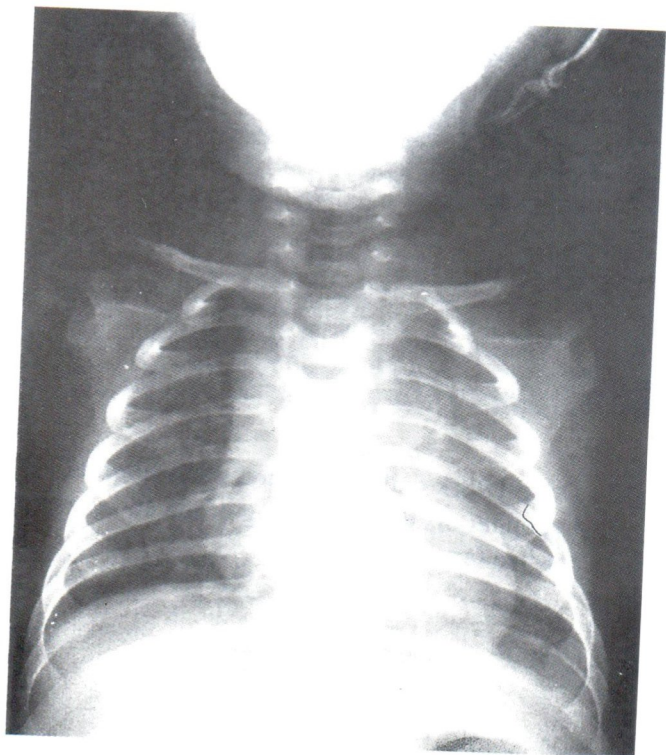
AP chest roentgenogram includes the neck showed no abnormalities.
